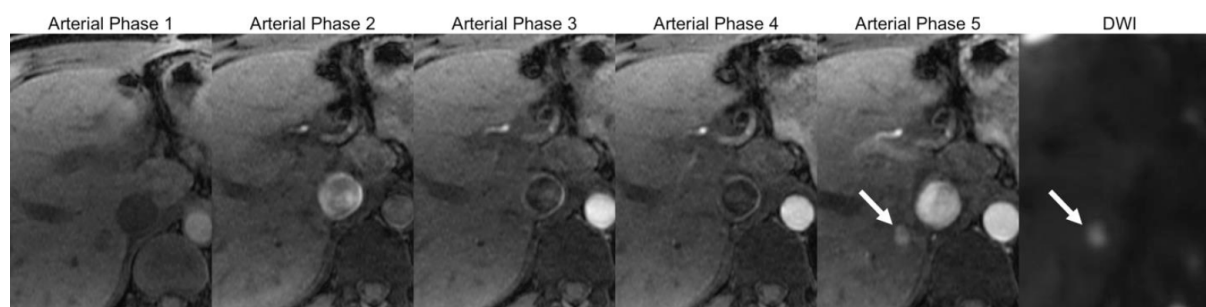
MRI multiarterial phase acquisition (Arterial phase 1-5): the multiphase acquisition in a single breath hold allows capturing the optimally timed arterial phase for HCC detection (in this example, arterial phase 5). A 8 mm observation with nonrim APHE is seen in segment 6, confirmed as a suspicious observation due to restricted diffusion (arrows). MRI: magnetic resonance imaging; HCC: hepatocellular carcinoma; APHE: arterial phase hyperenhancement; DWI: diffusion weighted imaging
